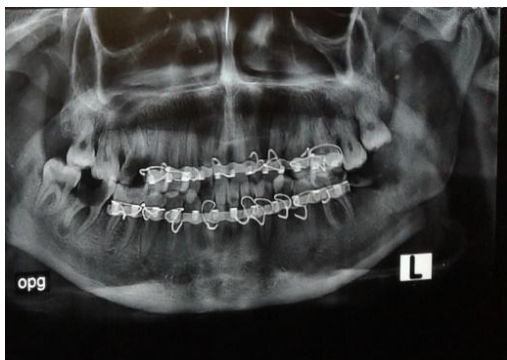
Preoperative Radiograph of angle fracture
